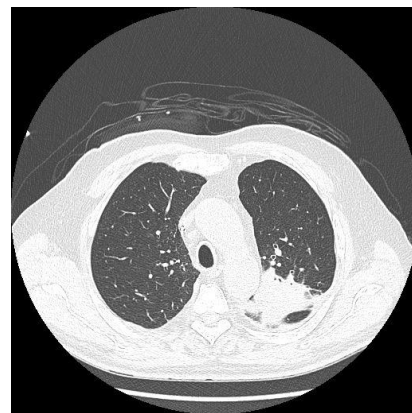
Computed tomography scan of thorax (04/2024): progression of left upper lobe tumor to 54 mm in transverse plane, with infiltration of vascular structures of left lung hilum.
